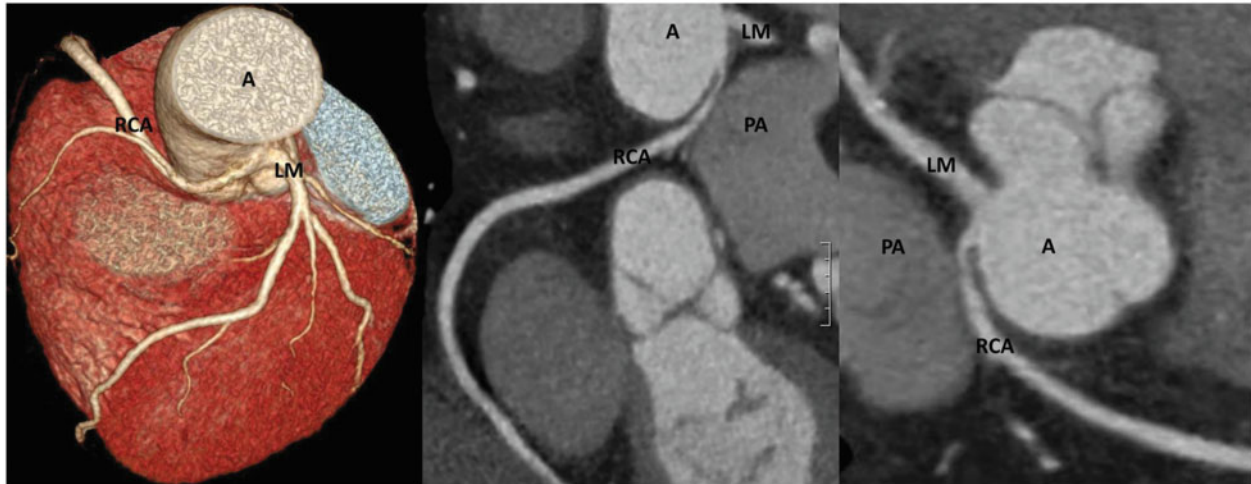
Three-dimensional constructed computed tomography imaging acquisition of the heart on volume rendering view showed right coronary artery origin from the left sinus (left). Curved multi planner reformation view showed right coronary artery anomalous at the proximal segment traverse between the pulmonary artery and aorta, and severe stenosis at the ostial right coronary artery (middle, right). A, aorta; LM, left main; PA, pulmonary artery; RCA, right coronary artery.
